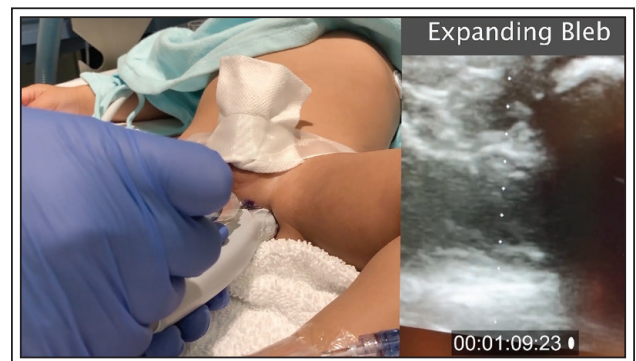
Ultrasound guided pudendal nerve block technique. During injection of local anesthetic there is visualization of an expanding bleb within the ischiorectal fossa.
